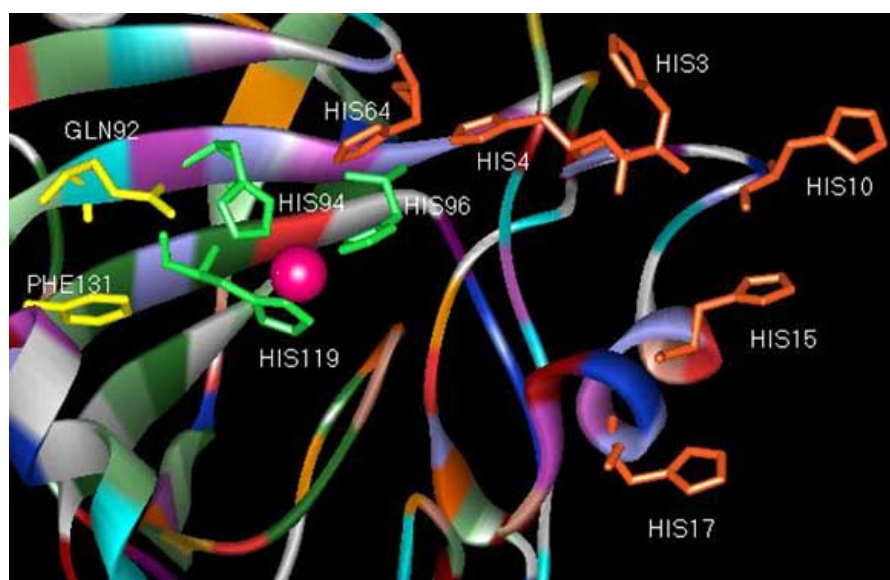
Details of hCA II active site. The Zn(II) ion (central pink sphere) and its three histidine ligands (in green, His 94, His 96, His 119) are shown. The histidine residues (His 64, His 4, His 3, His 17, His 15 and His 10) involved in proton transfer reactions between the active site and the reaction medium are also evidenced. The figure was generated from the X-ray coordinates reported by Briganti *et al.* (PDB entry 4TST) [28].
